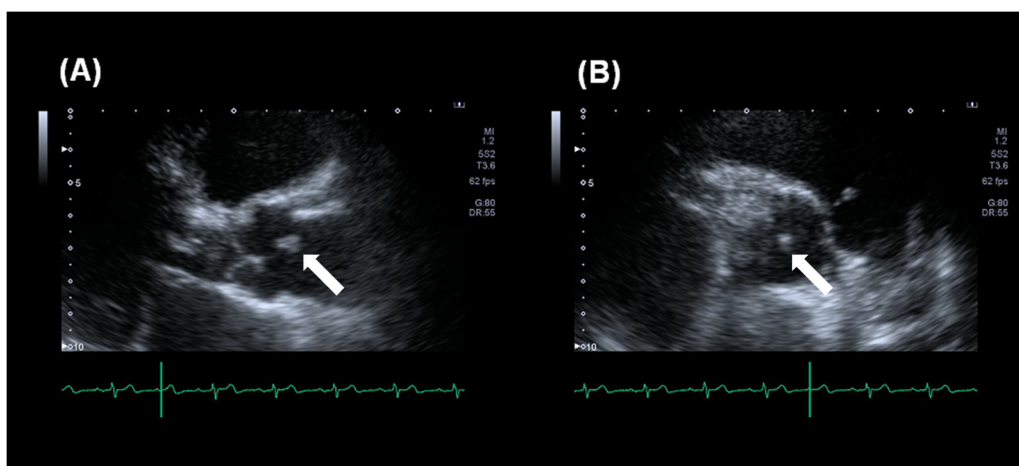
(A) Parasternal long-axis view in two-dimensional transthoracic echocardiography (magnified at the aortic valve) showing a hyperechoic mass attached to the aortic valve (arrow). (B) Parasternal short-axis view in transthoracic echocardiography (magnified at the aortic valve) showing a hyperechoic mass attached to the aortic valve (arrow).
